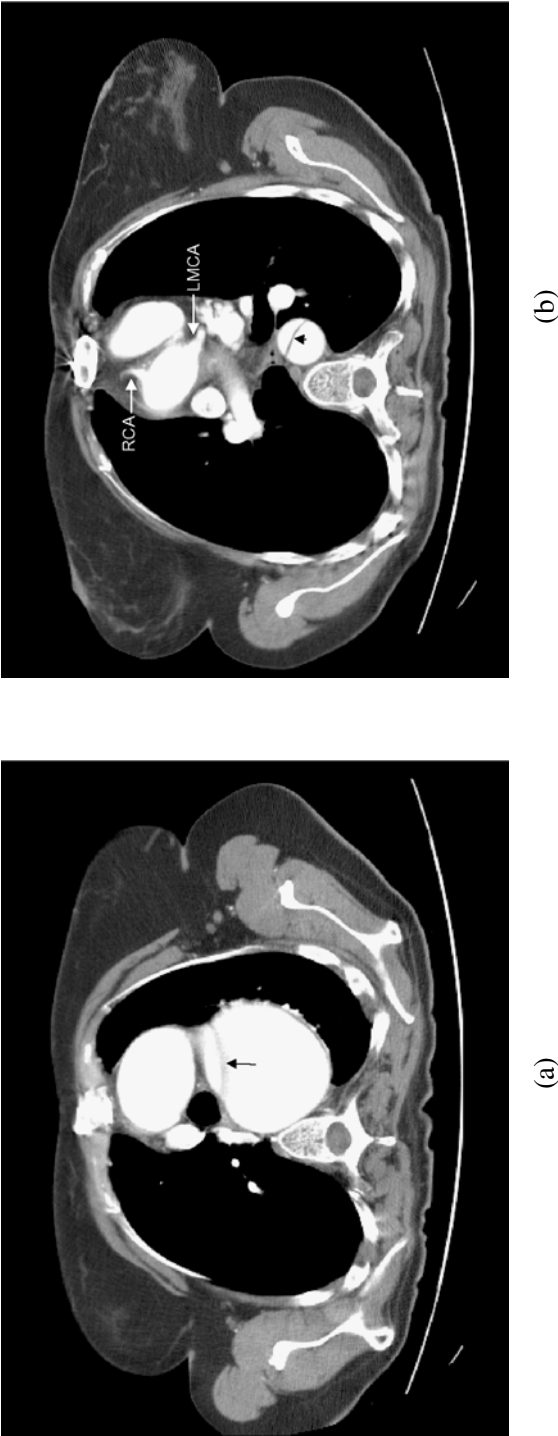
38-year-old woman with Marfan syndrome, who five years previously had an elective valve sparing repair of the root and ascending aorta. Postoperative CT scans were performed yearly. Her blood pressure was always low/normal on chronic beta blockade. Postoperatively, she developed moderate (3+) aortic regurgitation due to dilation of the sinuses of Valsalva. The patient was hesitant to undergo repeat surgery. (a) CT scan with contrast at the level of the distal aortic arch. There is an intimal flap in the severely dilated, proximal descending thoracic aorta, which was not clinically suspected. (b) CT scan with contrast at the level of the aortic root. Note the origins of the left and right coronary arteries (arrows). The descending thoracic aorta is of normal caliber at this level, though the intimal flap remains obvious (arrowheads). This cut does not demonstrate the root pathology responsible for her postoperative aortic regurgitation, though it was felt due to continued dilatation of a cuff of native tissue left at the time of her initial repair.
